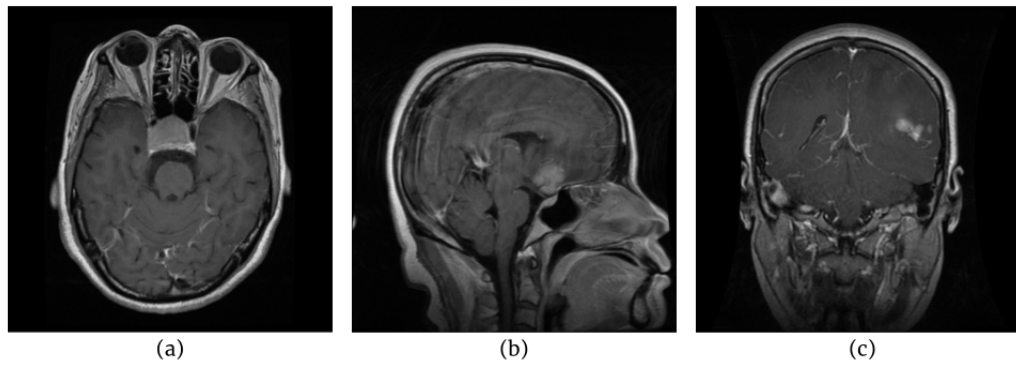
Anatomical planes, brain MRI.
